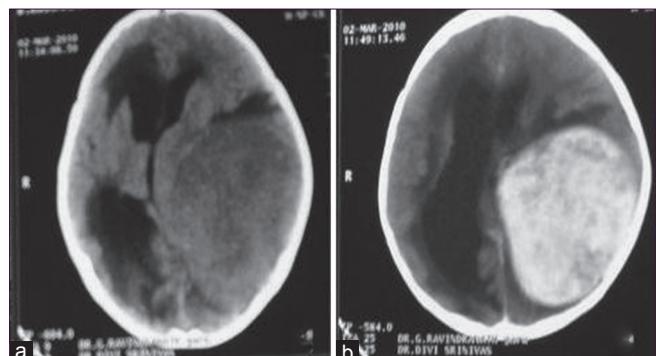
(a and b) Computed tomography scan brain showing an iso-intense extra-axial lesion involving the left parieto-occipital region with intense homogenous contrast enhancement, causing effacement of ipsilateral ventricle and hydrocephalus
